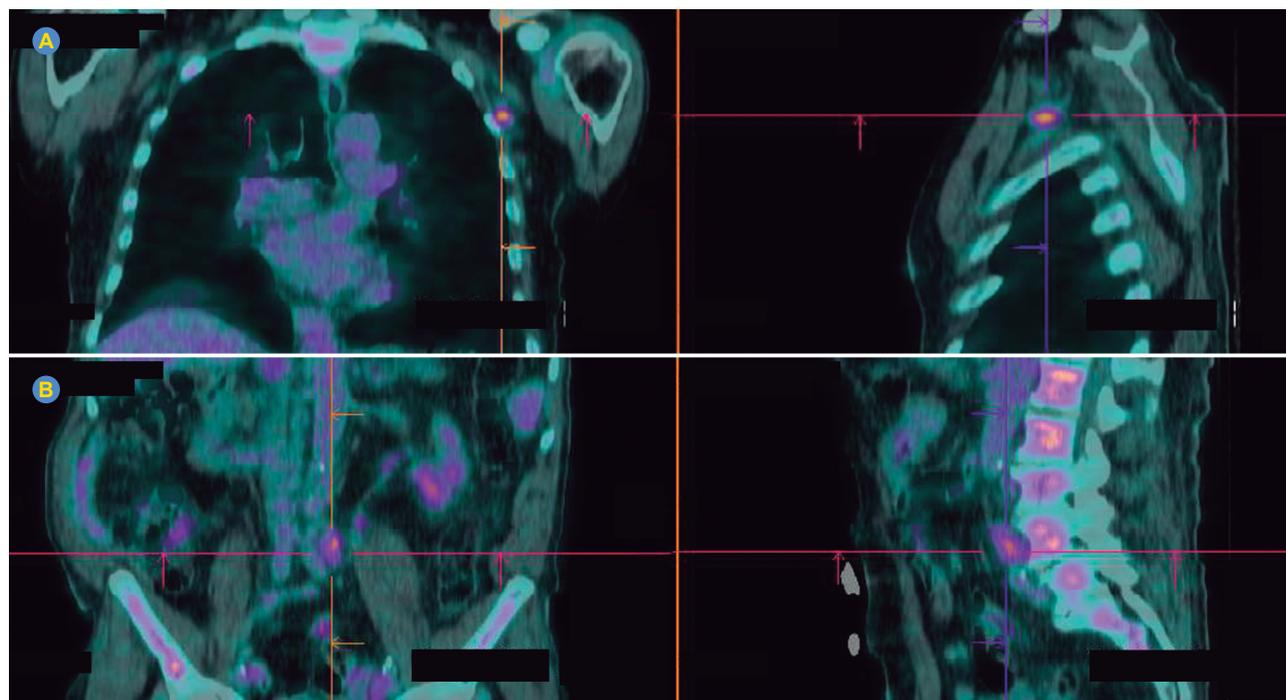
18F-FDG PET/CT scan, coronal (on the left) and sagittal (on the right) views, displaying metabolic hypercaptation (A) in left axillary lymph nodes (maximum standardized uptake value (SUVmax) of 4.8), (B) left common iliac and ilio-obturator chains (SUVmax 5.0) and also diffusely throughout the axial skeleton.
